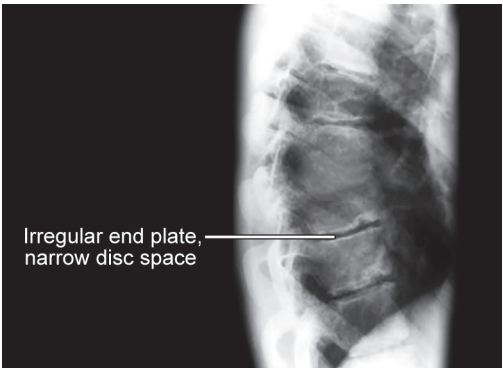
X-ray: Scheuermann's disease
